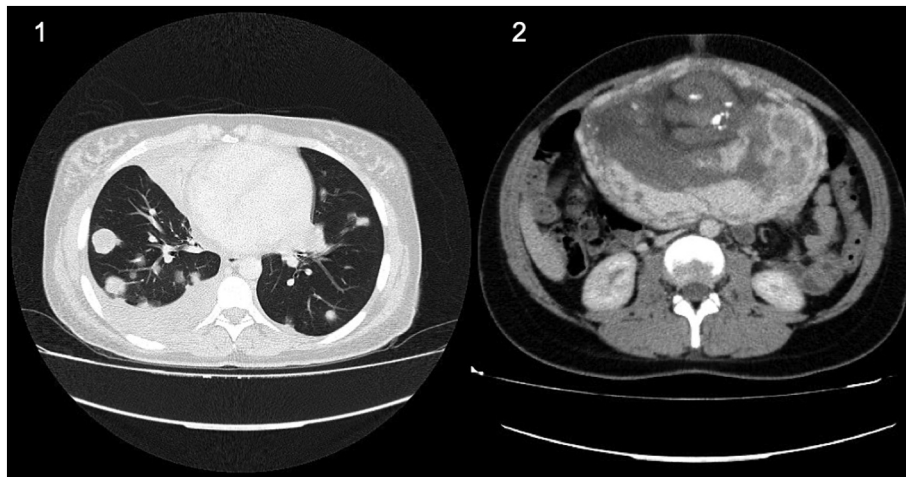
Full-body CT scan: (1) bilateral pulmonary metastases and bilateral pleural effusion. (2) heterogeneous posterior placenta with mamelons and nodular growth.
